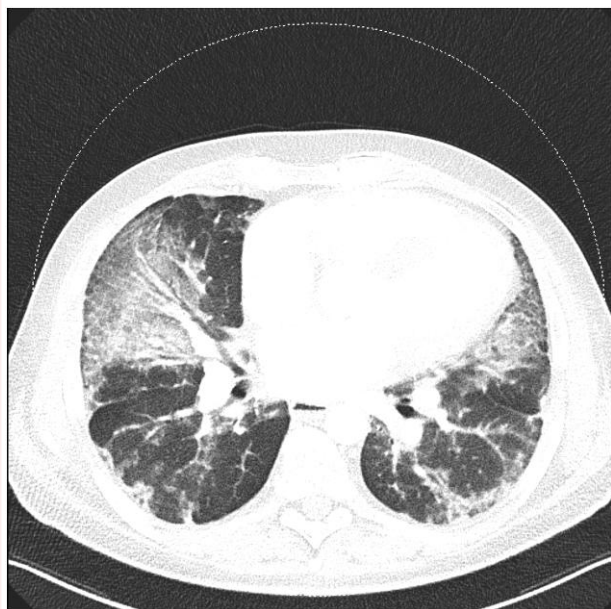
The ‘crazy-paving’ pattern in idiopathic pulmonary fibrosis on computed tomography scan before lung transplantation.
